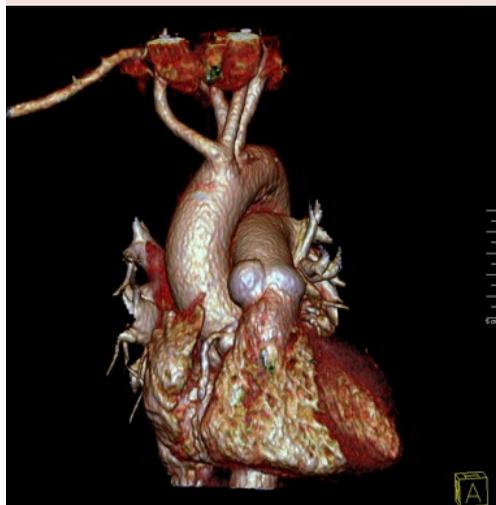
CT angiogram with 3D reconstruction demonstrating common origin of bilateral carotid arteries and a distal common origin of bilateral subclavian arteries.
